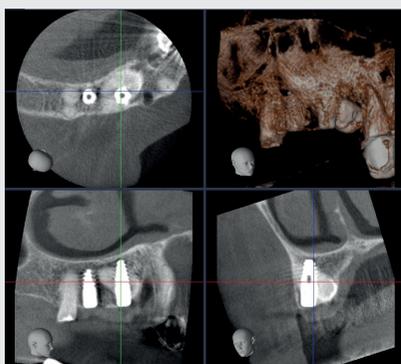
Control CBCT small FOV
